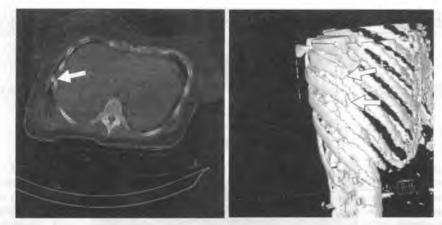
Rib fractures (arrow) on axial CT section - A, and on 3D SSD reconstruction (arrows) - B
